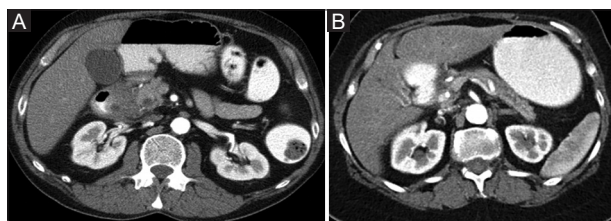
(A) Contrast medium-enhanced computed tomography (CT) scan in the arterial phase, showing a hypodense mass forming paraduodenal pancreatitis with thickening of the duodenal wall, duodenal cysts, medial displacement of the gastroduodenal artery, duodenal stenosis and stomach dilation, with stasis of the oral contrast medium. (B) Contrast medium-enhanced CT scan in the arterial phase showing a hypodense mass in the groove and duodenal thickening as a consequence of pancreatic groove necrosis.
